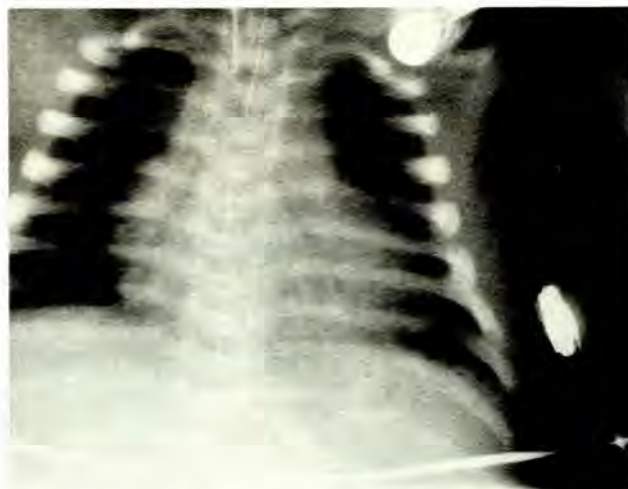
Admission chest radiograph showing a bilateral streaky infiltrative pattern with opacification of the right upper lung lobe with associated air bronchogram. The cardiothoracic index is increased.
